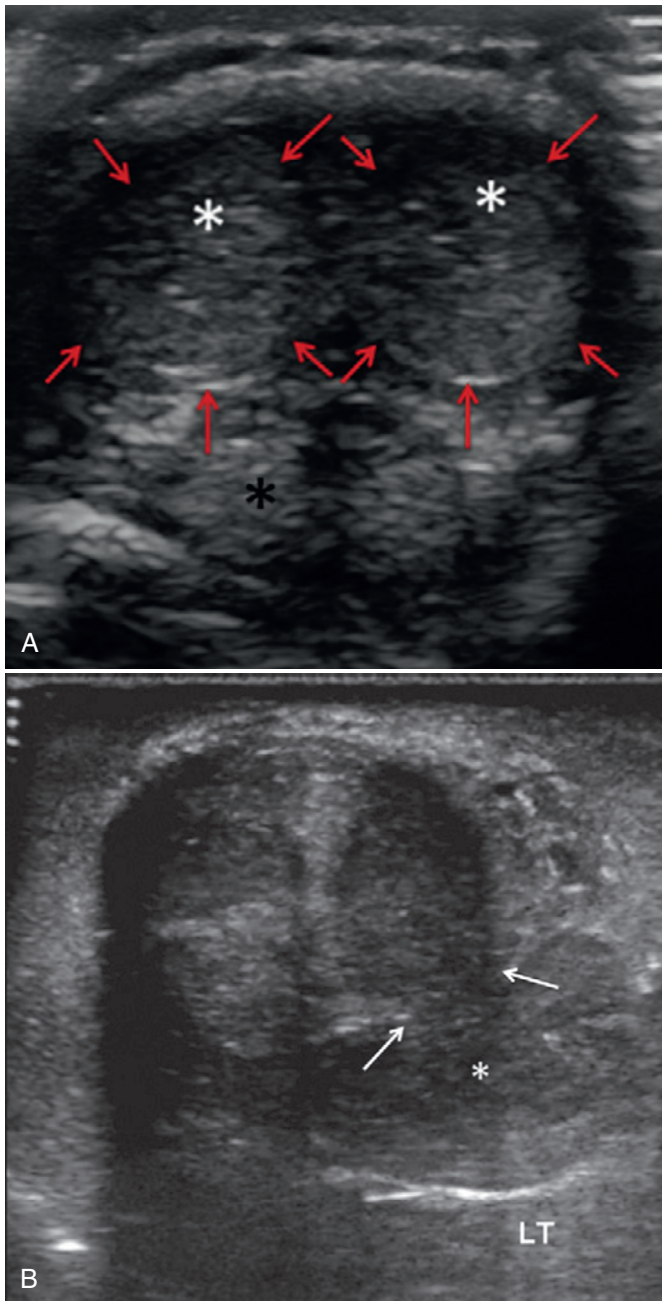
A, Normal penile ultrasound. Arrows outline the tunica albuginea, asterisks over the corpora cavernosa (white asterisks) and corpus spongiosum (black asterisk). B, Disruption of the tunica albuginea (arrows) and extruded corpus cavernosum tissue (asterisk) suggest penile fracture. (From Avery LL, Scheinfeld MH: Imaging of male pelvic trauma. *Radiol Clin North Am* 50:1201–1217, 2012.)
